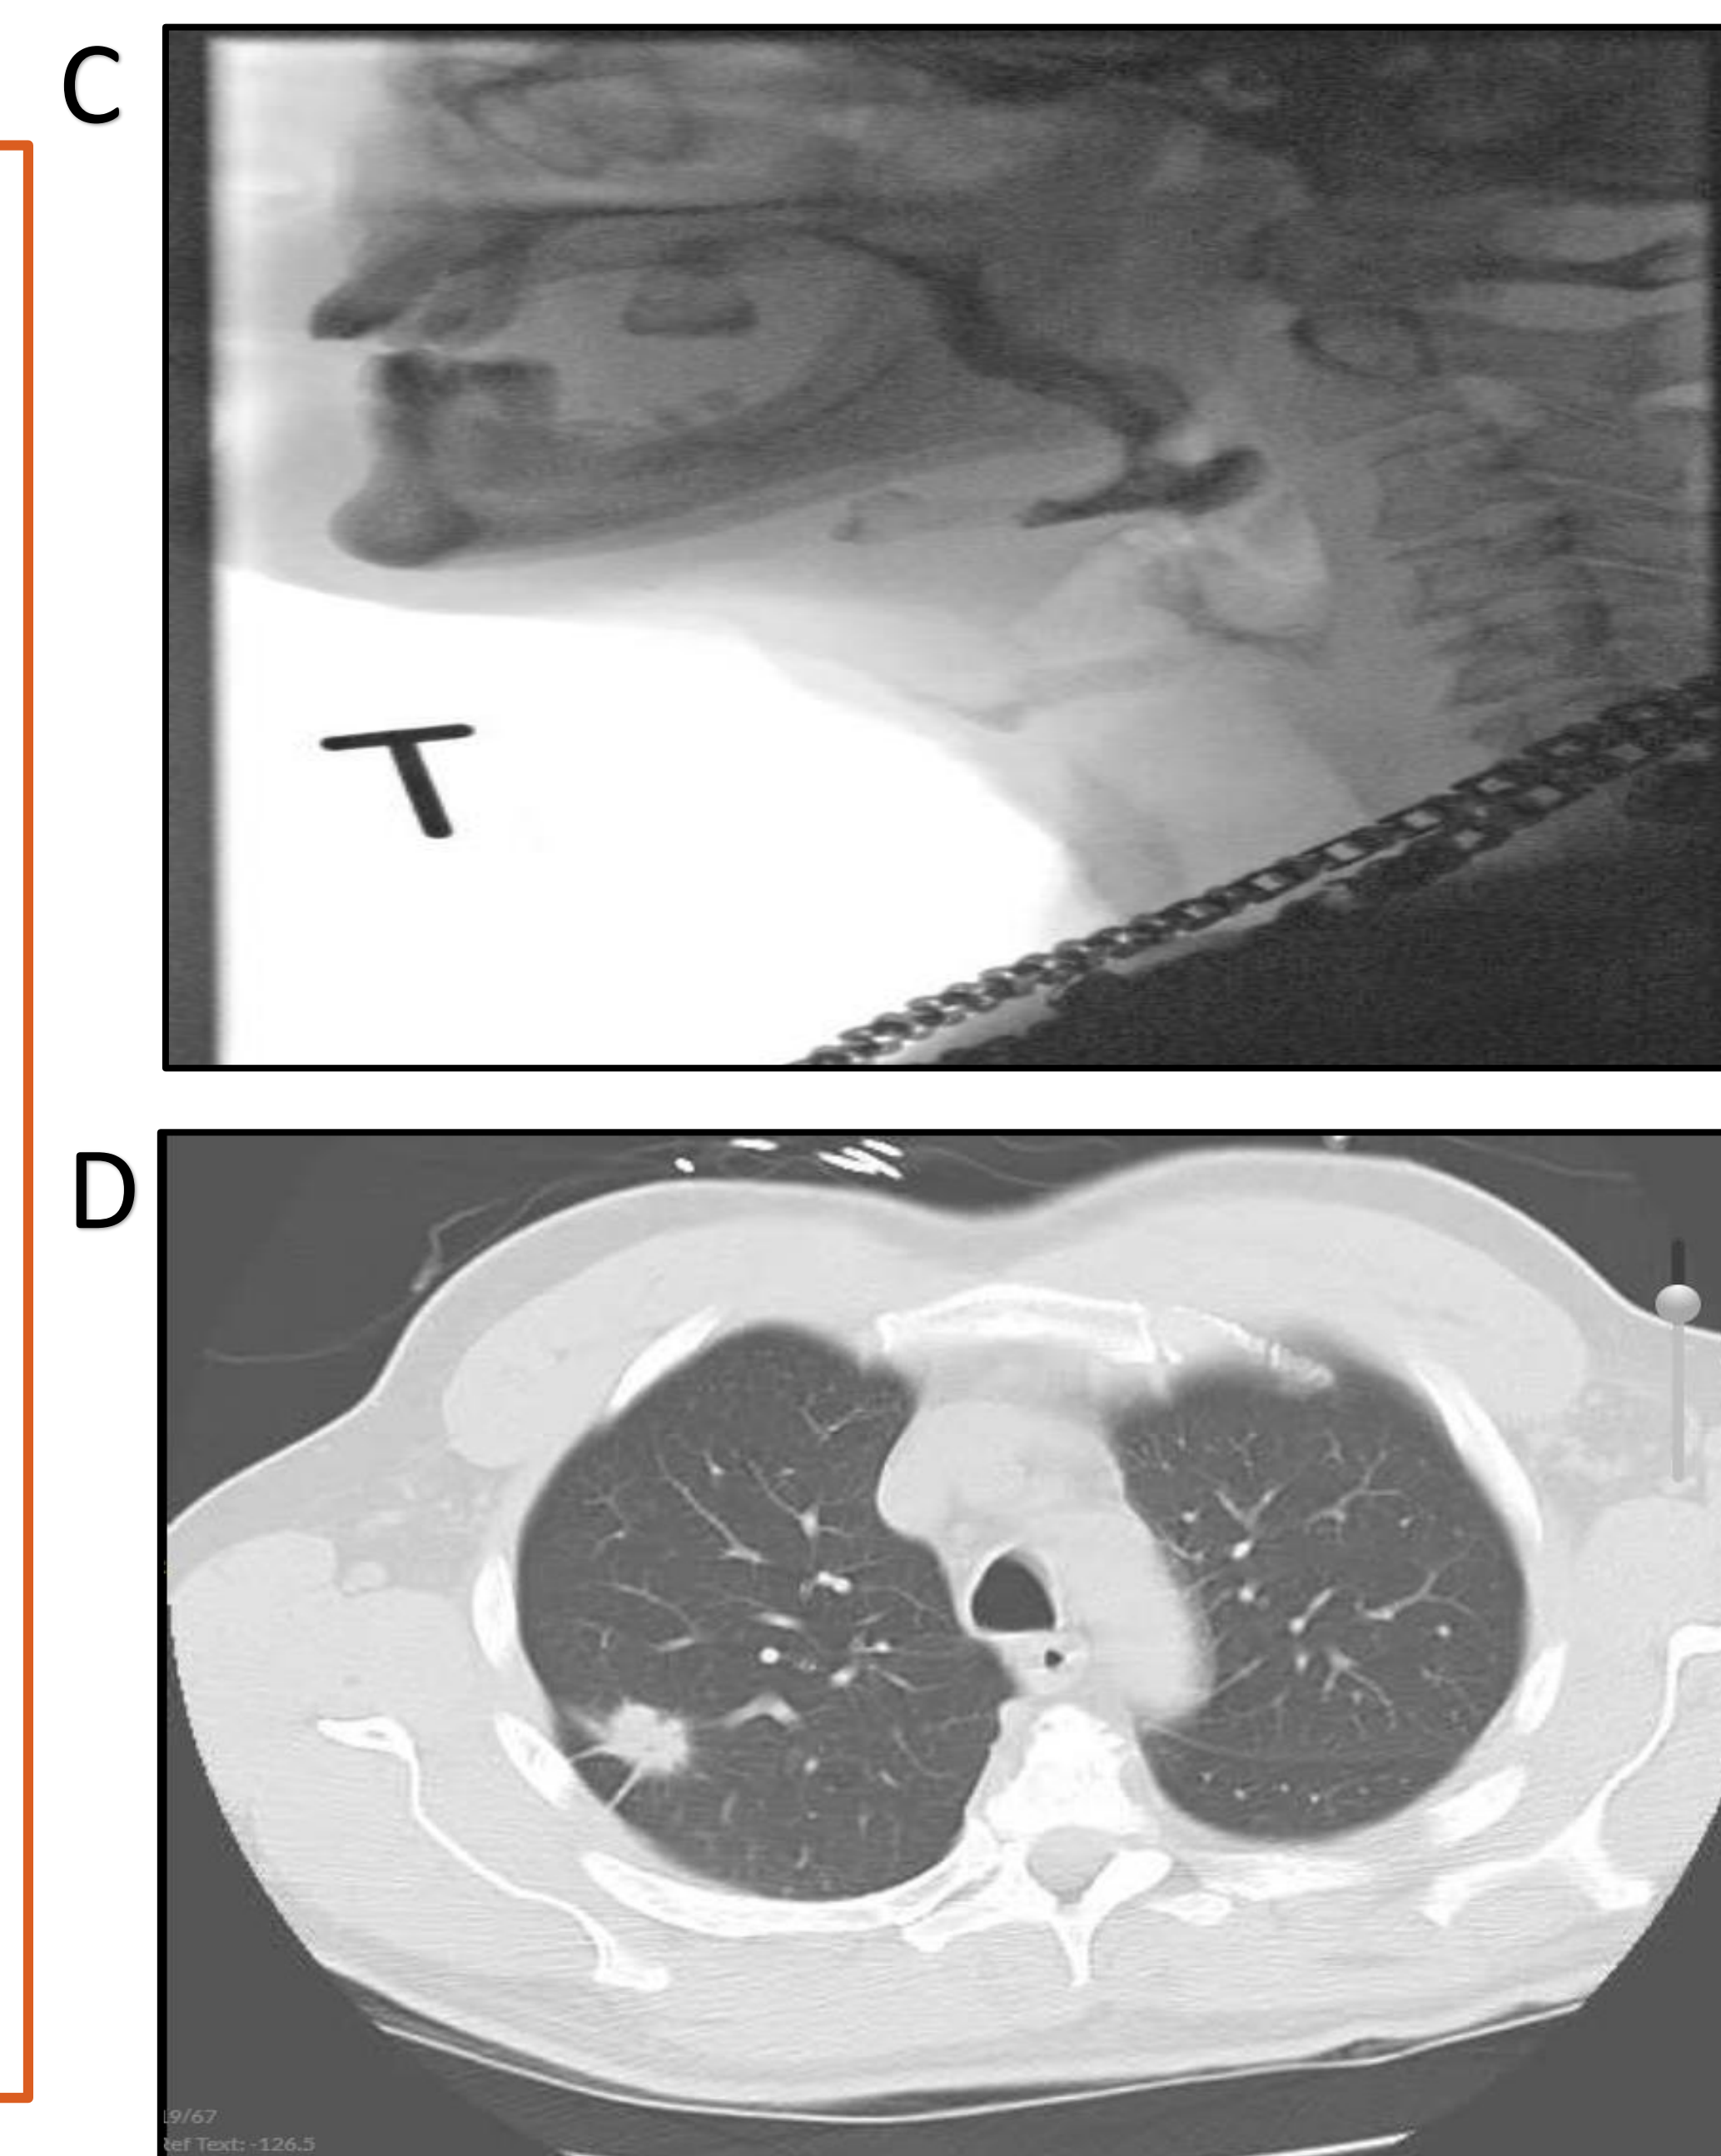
Barium swallow study demonstrating no anatomic or functional abnormalities (C). CT scan of chest demonstrating incidental finding of a spiculated lesion in the right lung (D).
